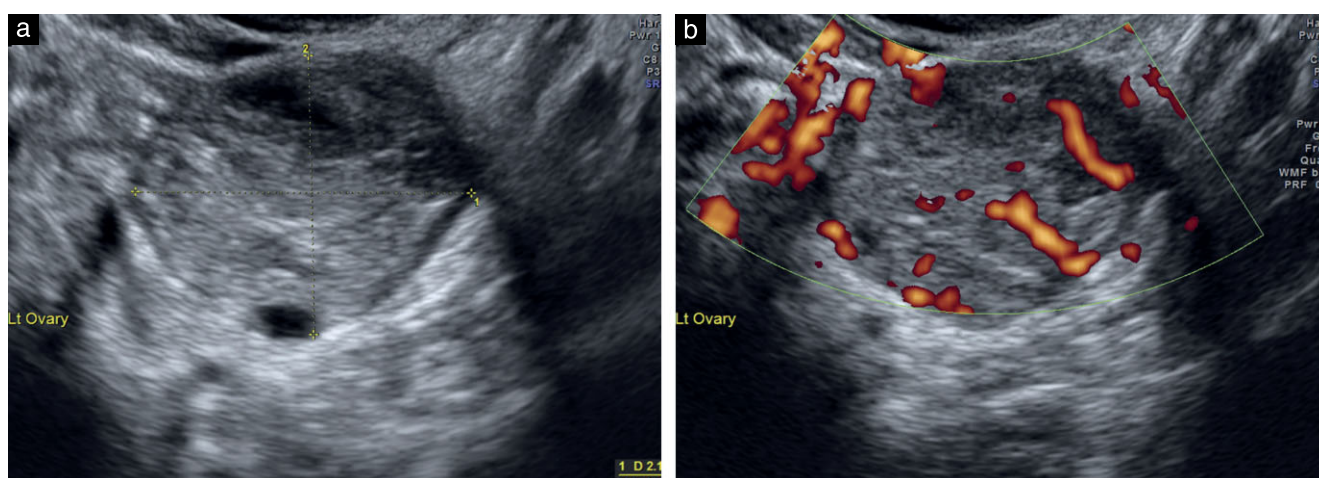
Ultrasound images of serous recurrent borderline ovarian tumor. (a) Single recurrent lesion surrounded by normal ovarian parenchyma (ovarian crescent sign). (b) Multiple recurrent lesions within the ovary.
